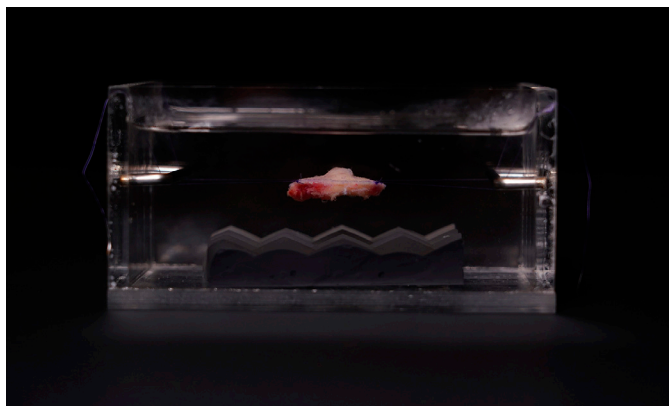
An excised lesion suspended in a saline solution in an acrylic container. An ultrasound-attenuating pad is placed in the bottom under the lesion.
